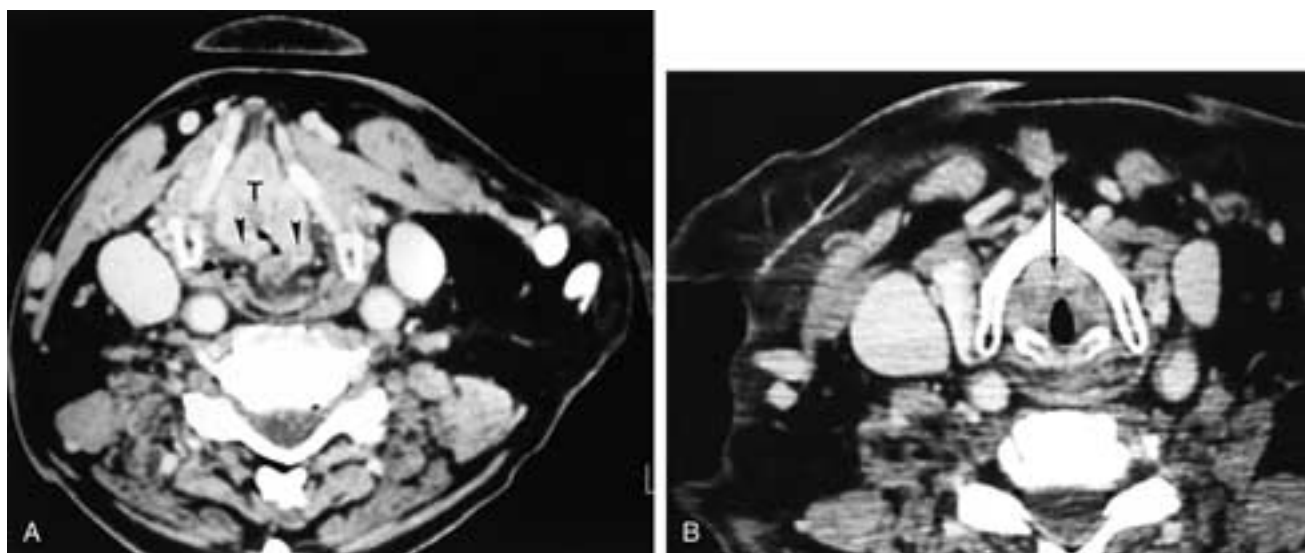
Axial CT scans. A, Supraglottic tumor (*T*) crosses the midline and involves both AE folds (*arrowheads*). B, More inferior scan at the level of the true cord shows involvement of the anterior commissure (*arrow*).
